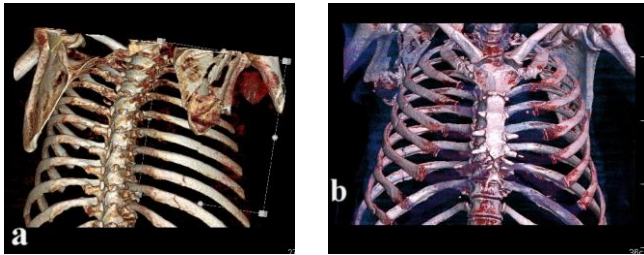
Patient 6. 3D computed tomography reconstruction: a – posterior view showing fractures of the body of the right scapula and Th4, Th5 spinous process fractures; b – anterior view showing right clavicular and first rib fractures
